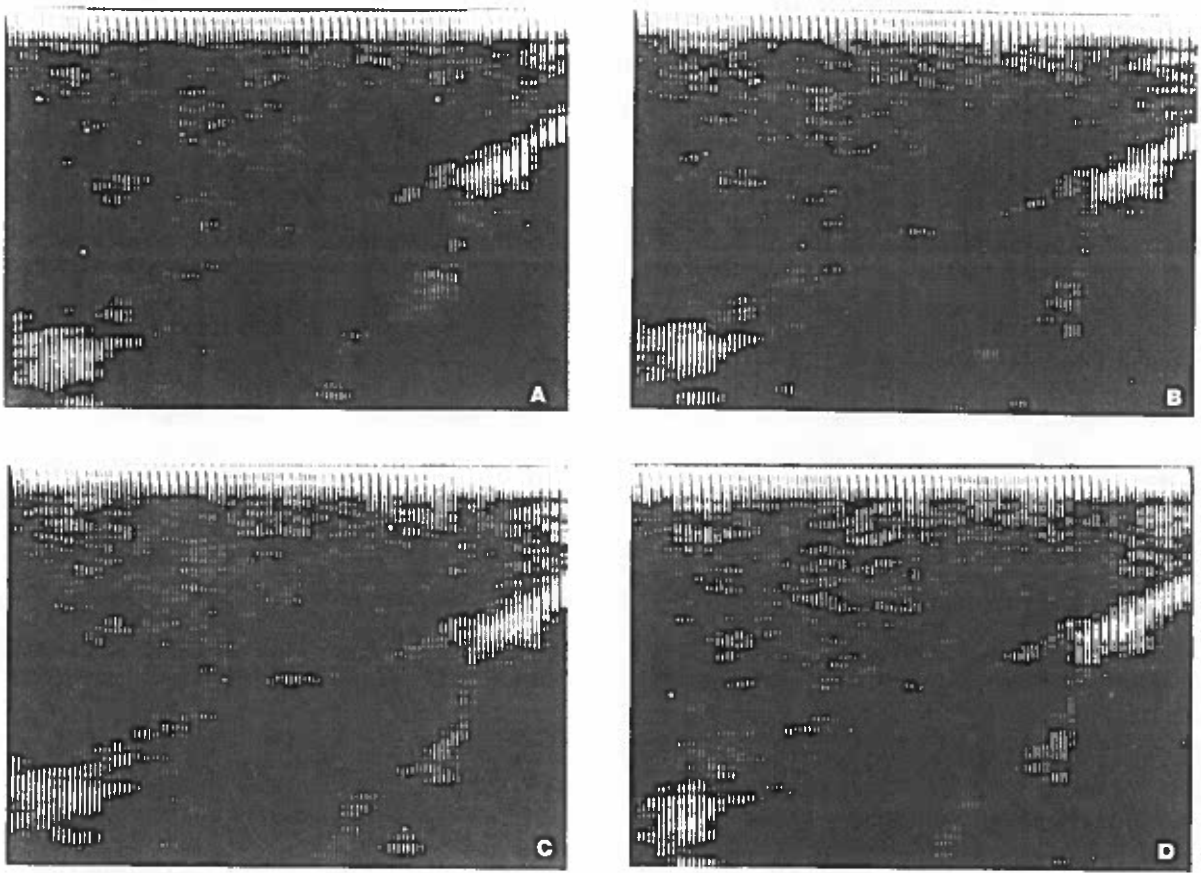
Effects of collagen microsphere infusion on canine liver sonograms at 7 MHz. (A) Control; (B) 4 minutes following end of infusion; (C) 9 minutes following end of infusion: note observable backscatter enhancement throughout the liver; (D) 25 minutes following end of infusion: continued effect. (Reprinted with permission from Ophir et al. 1980.)
